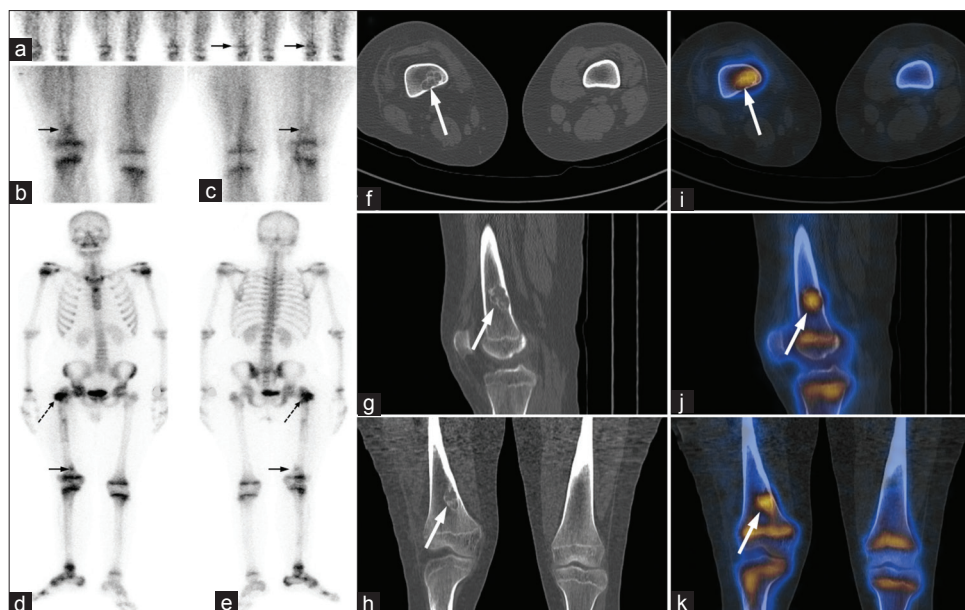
Three phase ^{99m}Tc -methylene diphosphonate bone scintigraphy images of the patient. Mildly increased flow (a, arrow) and pool (b and c, arrow) activity is seen in the region of right lower femur. On delayed image focal tracer uptake is seen in the lower shaft of right femur (d and e, arrow). Also noted was local recurrence in right proximal femur (d and e, broken arrow). No other site of skeletal metastasis was seen. To characterize the lower femoral lesion single photon emission tomography/computed tomography (SPECT/CT) was performed. CT (f-h) and SPECT/CT (i-k) images showed a sharply demarcated, asymmetrical, multiloculated, cortical based radiolucent lesion with sclerotic margins, located in the right femoral metaphysis and showing increased radiotracer uptake (arrow). These findings were classical for a non-ossifying fibroma. Furthermore, there is increased tracer uptake in the right lower limb joints proximal and distal to the femoral lesion-suggestive of associated sympathetic hyperactivity (d and e)
